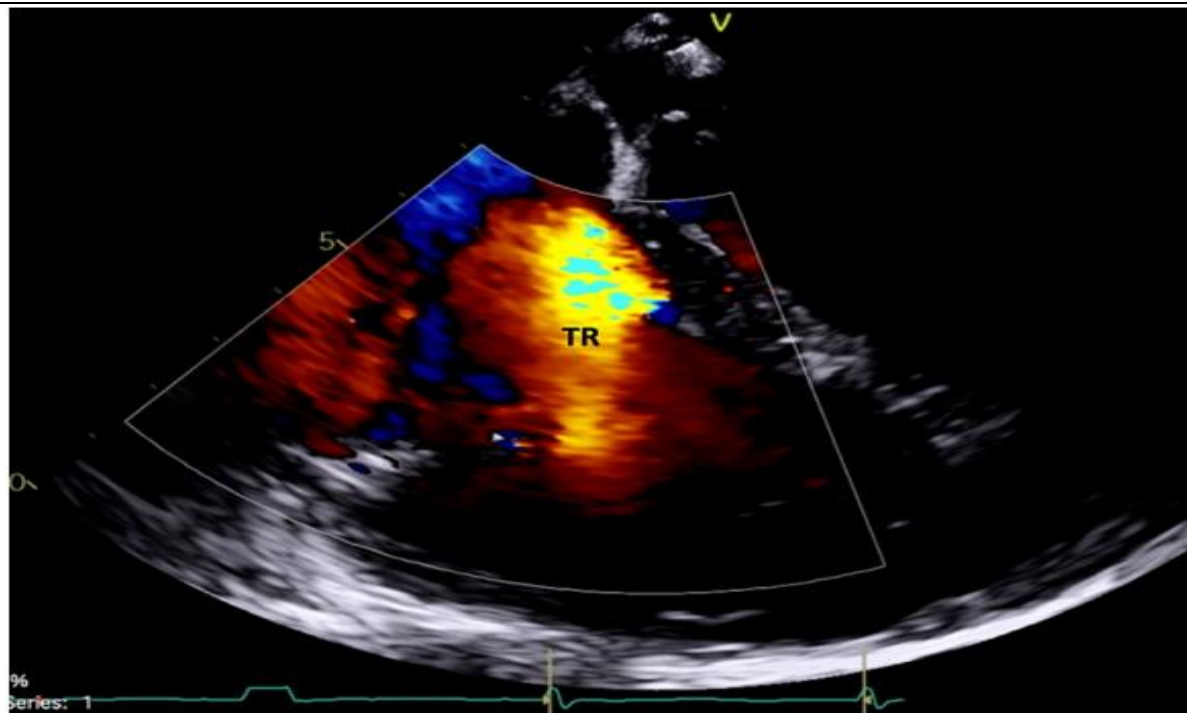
Severe TR on echocardiogram before valve repair. TR: tricuspid regurgitation
